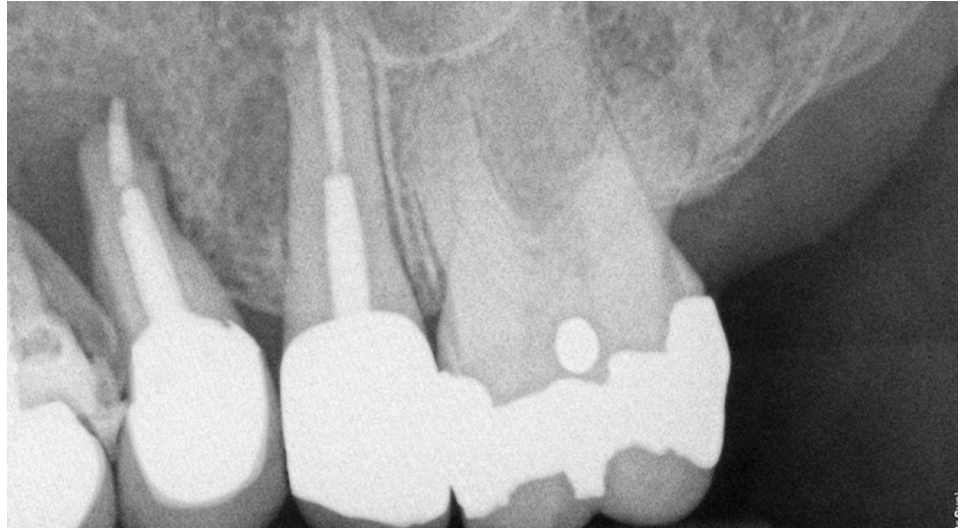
Initial radiographic presentation of patient demonstrating severe bone loss associated with #11 and #12.
